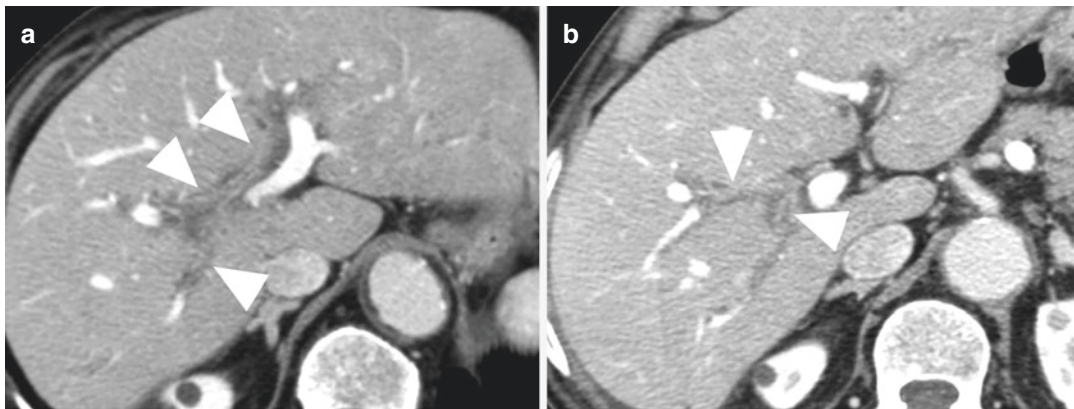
Primary sclerosing cholangitis in a 51-year-old man. (a, b) Axial contrast enhanced portal phase CT images obtained at different levels show mild intrahepatic
